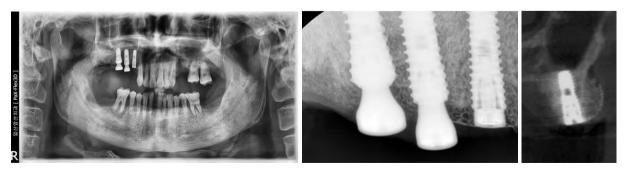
~15. Post-operative radiograph. On the post-operative CT scan, it is observed that the SmartBuilder contours an ideal shape of buccal alveolar bone and the bone graft material is well maintained under the SmartBuilder.
